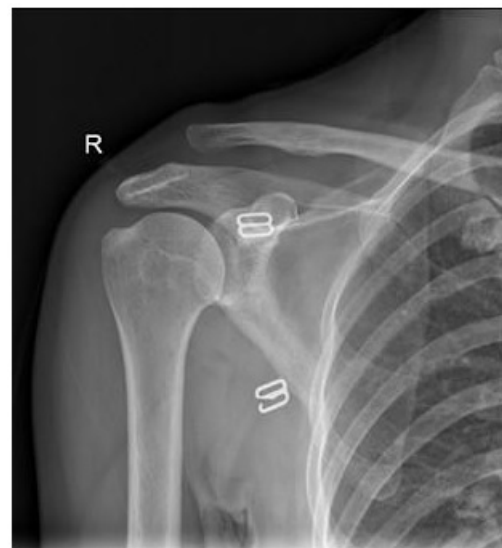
A X-ray in anteroposterior view of a right shoulder with an ACJ injury Rockwood Grade III.
